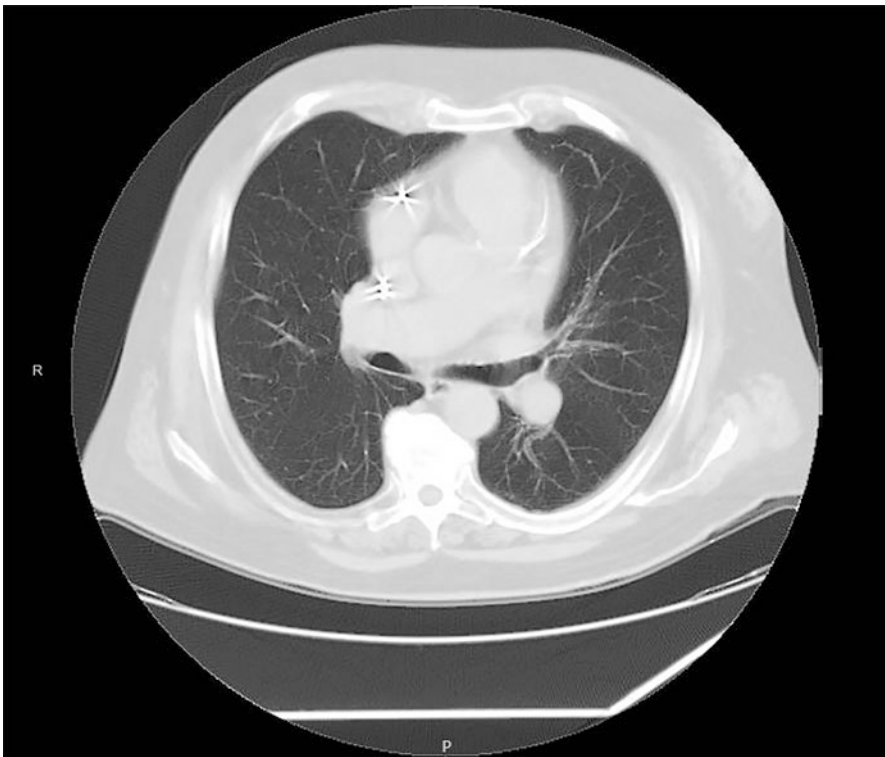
CT scan is showing the star artifact caused by pacemaker leads
